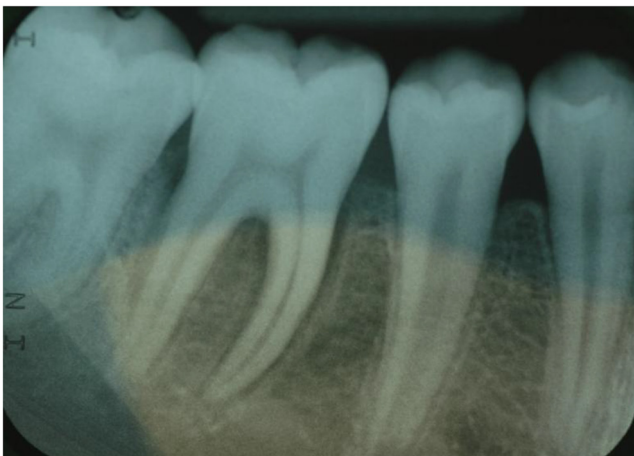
Initial radiographic exam of the affected sector.
